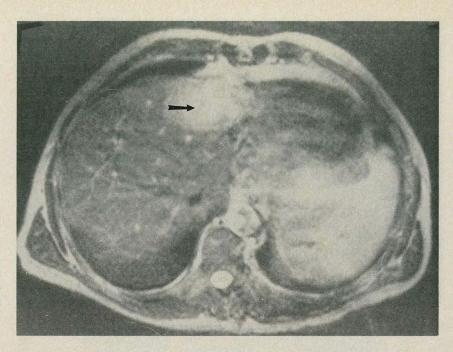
Axial T2-weighted image demonstrates relatively hyperintense lesion in left hepatic lobe, consistent with metastatic disease.
